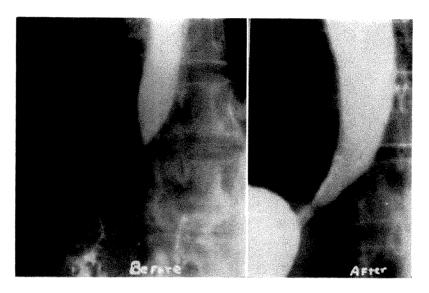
Cardiospasm, before and after nitroglycerine. G. O. D., female, aged forty-eight. Gradual onset of dysphagia about three years ago with increasing difficulty during past four months. Roentgen examination prior to giving nitrites revealed marked narrowing of the lower esophagus with almost complete obstruction and moderate dilatation above. After 1/100 grain of nitroglycerine was given, the lower esophagus dilated and the entire esophageal contents flowed into the stomach.
